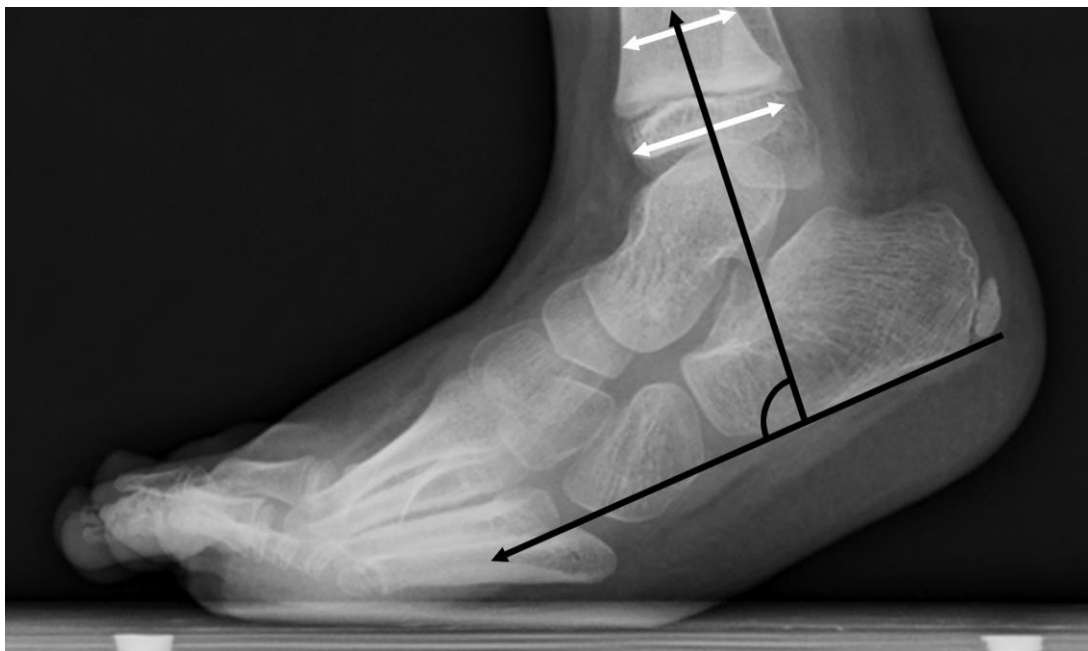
Standing lateral radiograph of an equinovarus left foot, showing the tibiocalcaneal angle (2).
